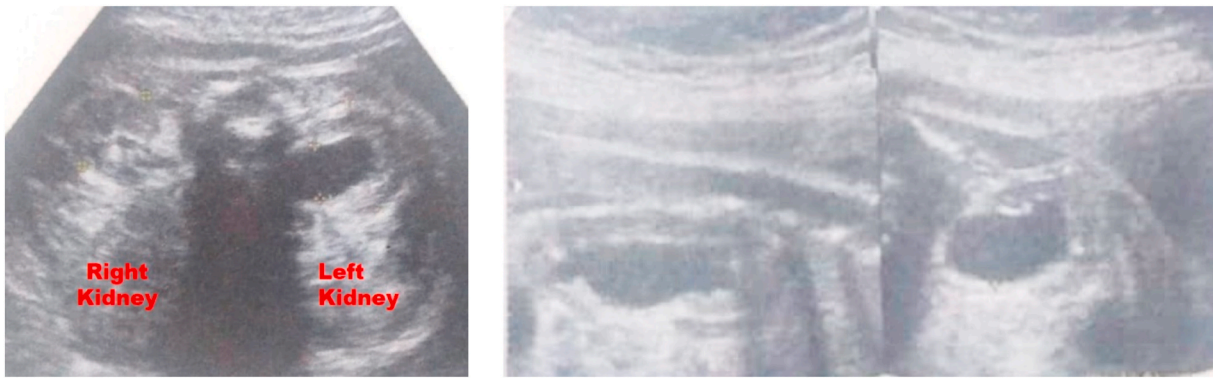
Antenatal ultrasound showing left-side hydronephrosis.
